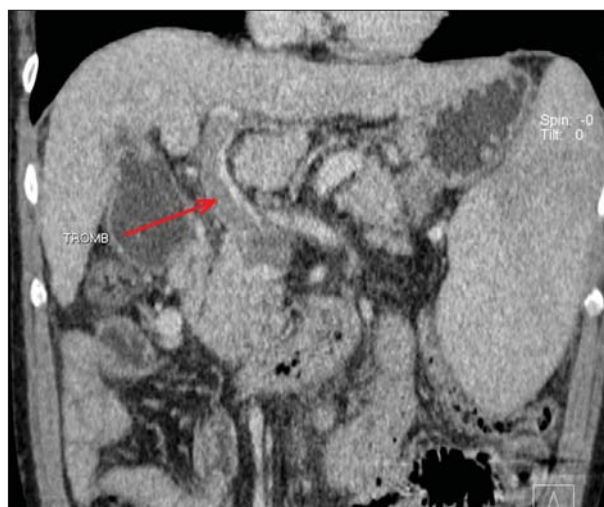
Contrast CT scan – portal thrombosis
